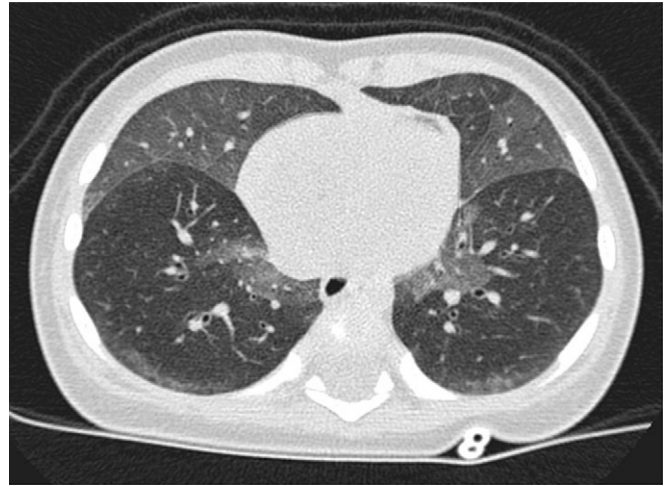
Neuroendocrine cell hyperplasia of infancy (NEHI). Single controlled ventilation high-resolution computed tomography image (at TLC) of the lower chest of a 4-month-old with tachypnea and hypoxemia. The scan demonstrates sharply defined areas of ground glass opacity most marked in the right middle lobe and lingula. Diffuse air trapping was seen on expiratory images, affecting both the ground glass areas and the remaining lung. No additional abnormalities were identified. NEHI was confirmed by lung biopsy.
